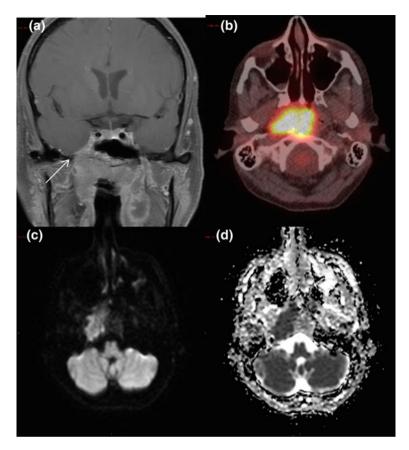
Nasopharyngeal cancer a Coronal T1 post contrast. b PET-CT. c Diffusion-weighted imaging (DWI). d Apparent diffusion coefficient (ADC). The lesion is FDG avid with extension across the midline (b). Notice the perineural spread through foramen ovale (*arrow in a*). Portions of the tumor demonstrate diffusion restriction at the skull base (c and d)
